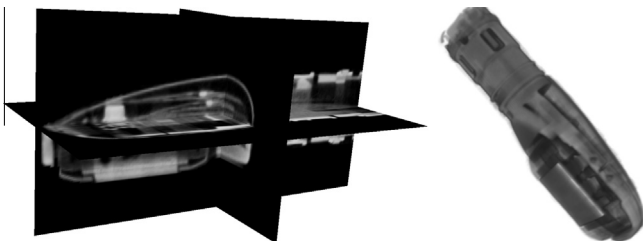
3D visualization of the processed C-arm CT volume of an X7-2t 3D TEE transducer (Philips, The Netherlands).
